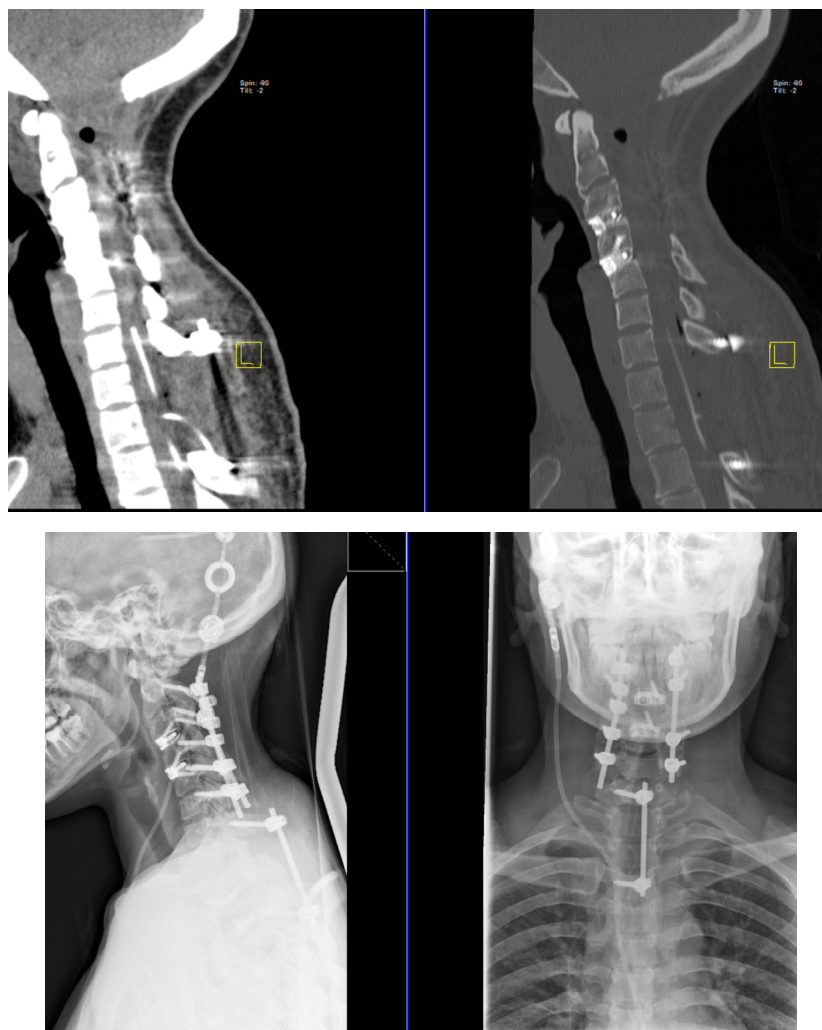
CT scan, X-Ray after syringopleural shunting.
